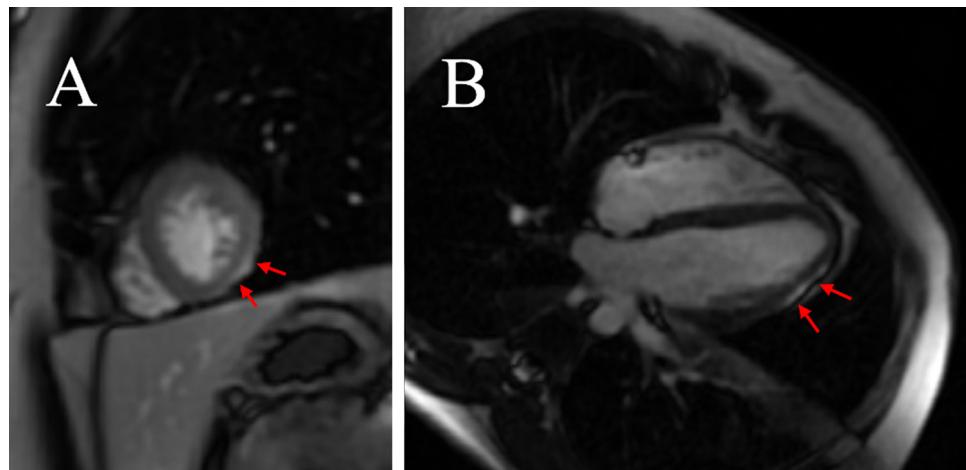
Cardiac magnetic resonance imaging short axis (A) and four chamber (B) views with late gadolinium enhancement sequences identifying a lateral subepicardial enhancement.
